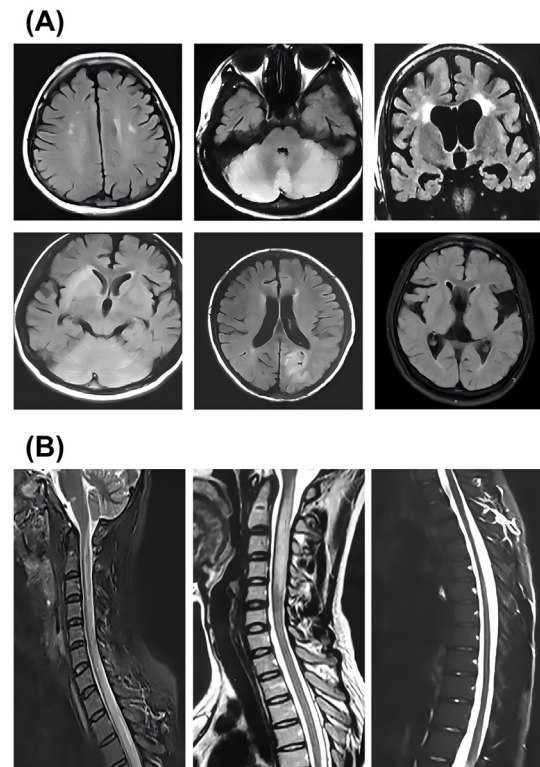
Neuroimaging Findings. (A) Brain MRI of some patients were characterized primarily by cerebral atrophy and white matter lesions. (B) Spinal cord MRI of some patients exhibited spinal cord atrophy and longitudinally extensive transverse myelitis.
